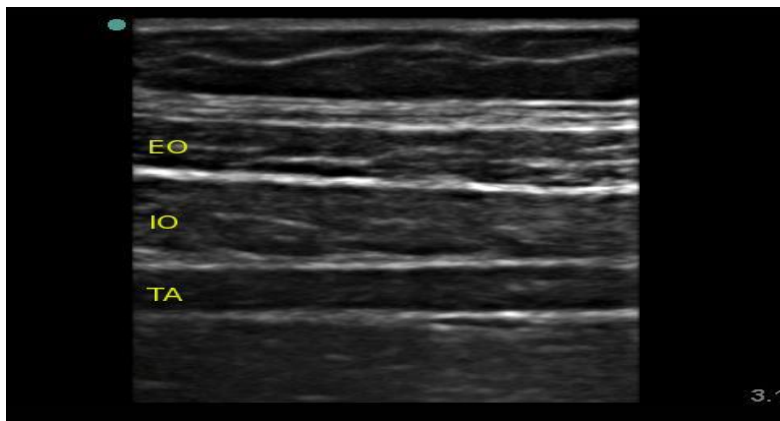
Ultrasound view of anterior abdominal muscle (*Taken from Journal of NYSORA, Transversus abdominis plane Block*)
